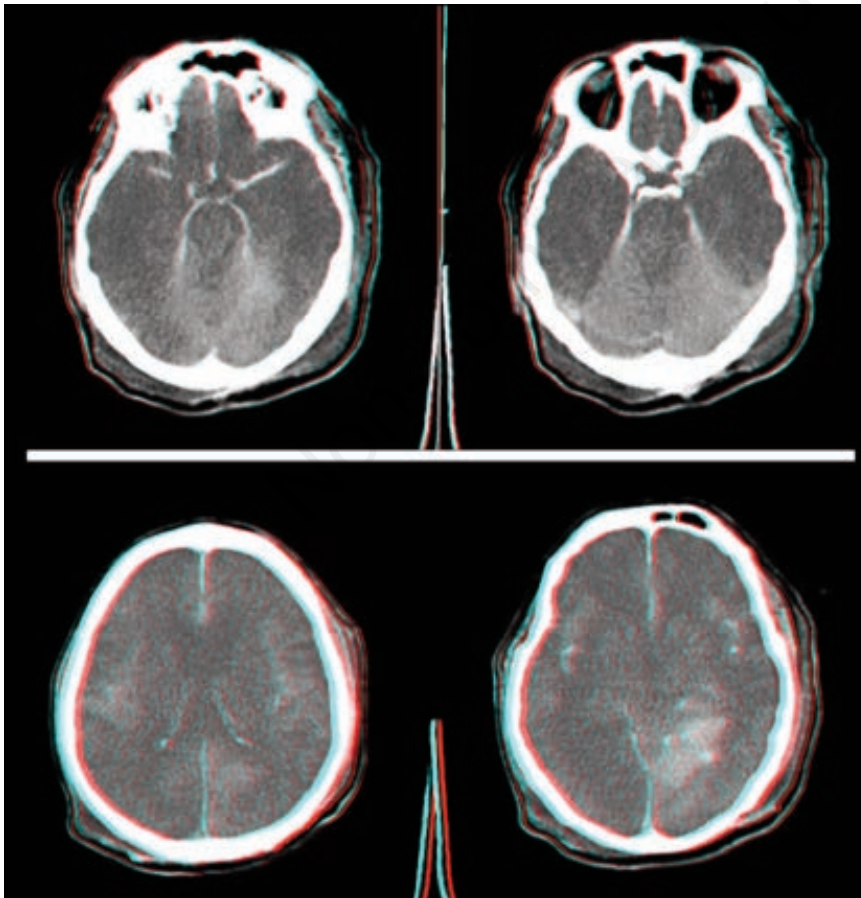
Cranial computed tomography scan revealing increased attenuation along the basal cisterna or cortical sulci, which mimics SAH. In the absence of a large amount of subarachnoid blood or a parenchymal haematoma, images of pseudo-SAH show the marked effacement of sulci and basal cisterns, invisible ventricles, and poor grey-white matter differentiation.
